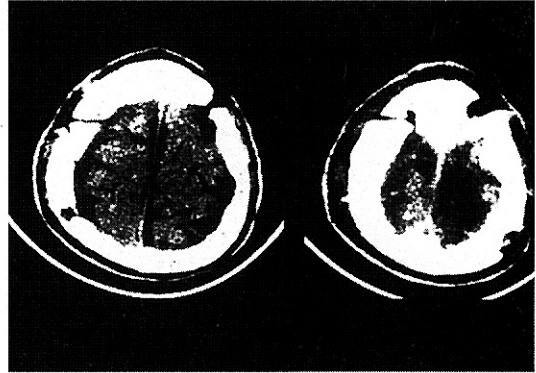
Postoperative CT scan shows complete evacuation of the hematoma.
